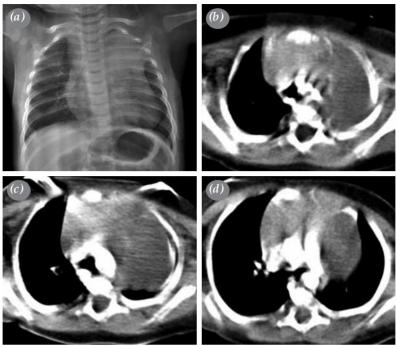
A 120-day-old male patient with mediastinal cavernous hemangioma; (a) chest radiograph and (b-d) axial computed tomography images.
